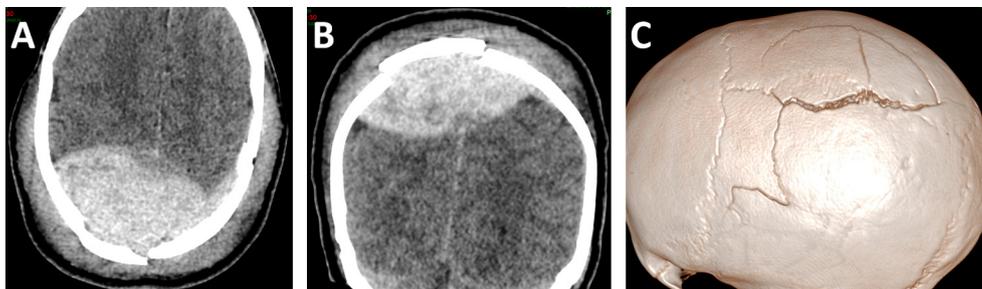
Computed tomography (CT) scan without contrast enhancement, displaying the vertex epidural hematoma and the comminuted bi-parietal skull fracture overlying the SSS. A. Axial view, brain window. B. Coronal view, brain window. C. 3D reconstruction of the cranial convexity.
